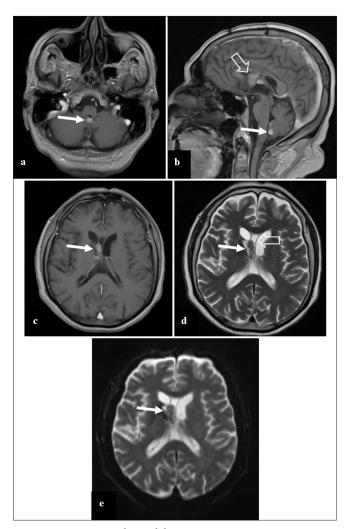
Contrast-enhanced brain magnetic resonance imaging in the 4th postoperative month. (a) Contrast-enhanced T1 image in axial view shows a new metastasis, nodular, contrast-enhancing in the inferior border of the IV ventricle (arrow). (b) Contrastenhanced T1 image in sagittal view shows the metastasis in the IV ventricle (arrow); in addition, the lesion recurrence in the right front horn is seen (empty arrow). (c) Contrast-enhanced T1 image in axial view shows the recurrence of the contrast-enhancing right frontal horn tumor (arrow), without associated ventricular dilation. (d) T2 image shows a recurrence of the right frontal horn tumor, isointense (thin arrow), that seems to invade the cavum vergae (empty arrow) and not the former surgical field. (e) Diffusionweighted image shows no signal restriction (arrow).
